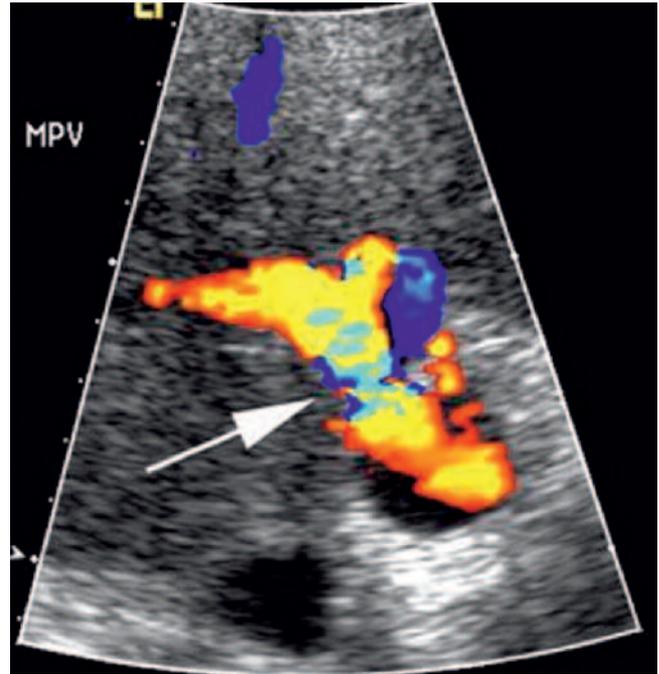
Doppler ultrasound of the portal vein demonstrating a focal area of stenosis of the middle branch of the portal vein.
